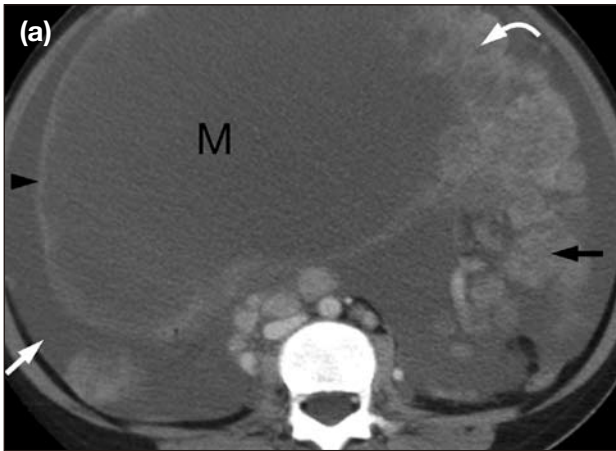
Contrast-enhanced axial computed tomography images of the lower abdomen showing (a) a large predominantly cystic ovarian mass (M) with peripheral enhancing capsule (arrowhead) and solid enhancing components (curved arrow); and (b) ascites (white arrow) and multiple omental metastases (black arrows).
